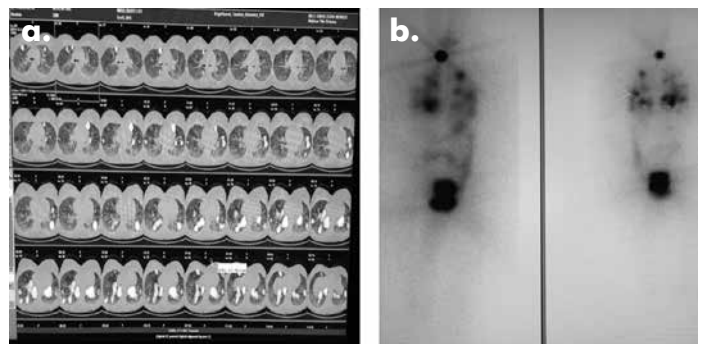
a) SPECT-CT examination: multiple metastasis in both lungs b) whole body scintigraphy
